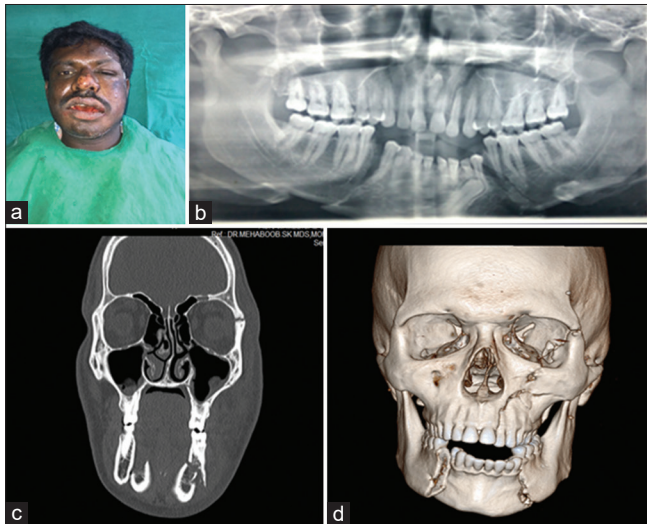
Pre-operative profile, (b) pre-operative radiograph, (c) multidetector computed tomography (MDCT), (d) 3D-MDCT
